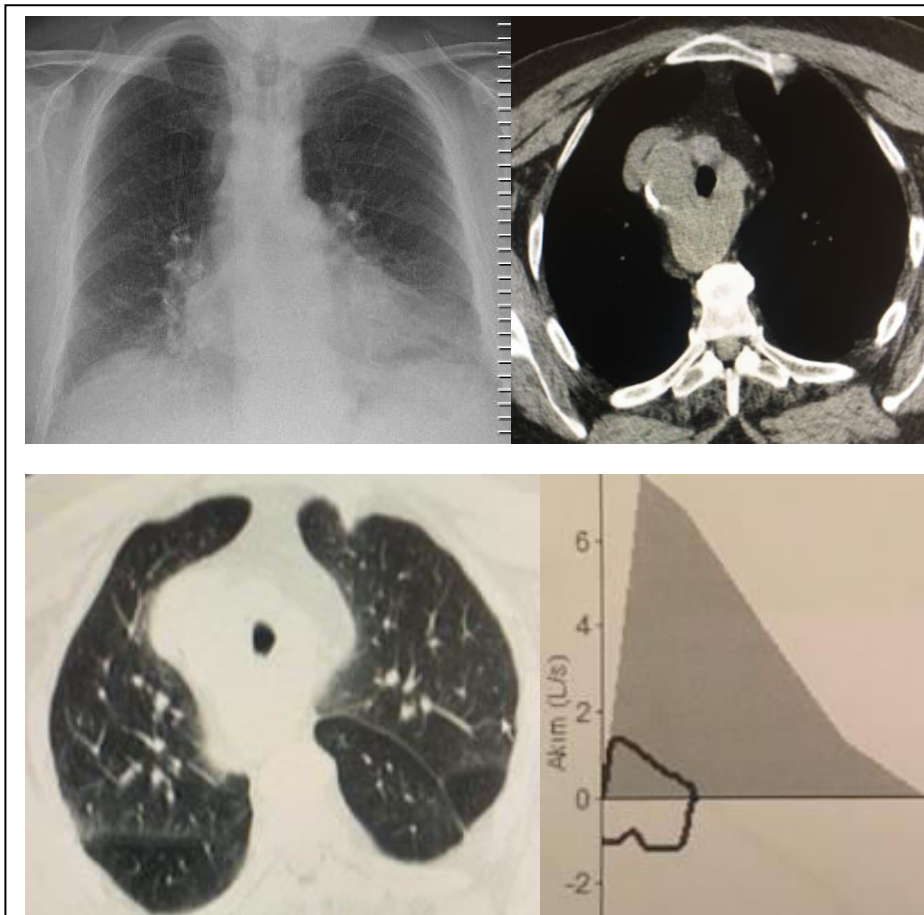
Chest radiography and Thoracic Ct images of 57 years-old male showing the right sided arcus aorta and flow-volume curves showing the quadrilateralization pattern on spirometry.
